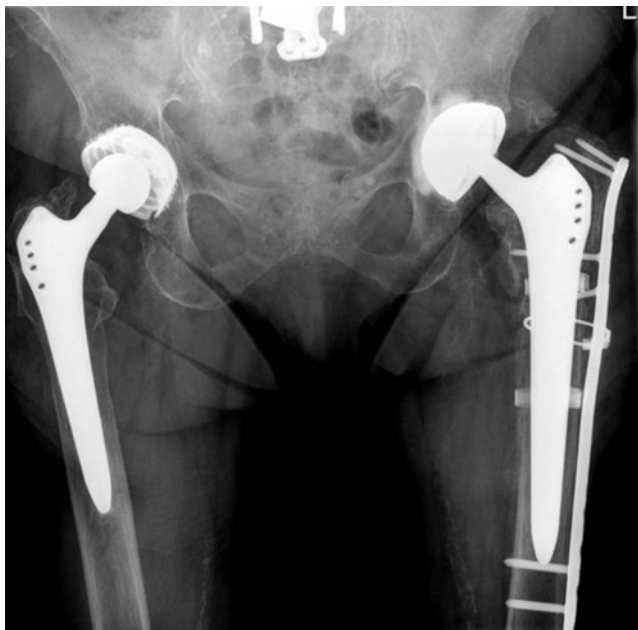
Postoperative X-ray image after open reduction and internal fixation using cerclage cables and plate (proximal).
